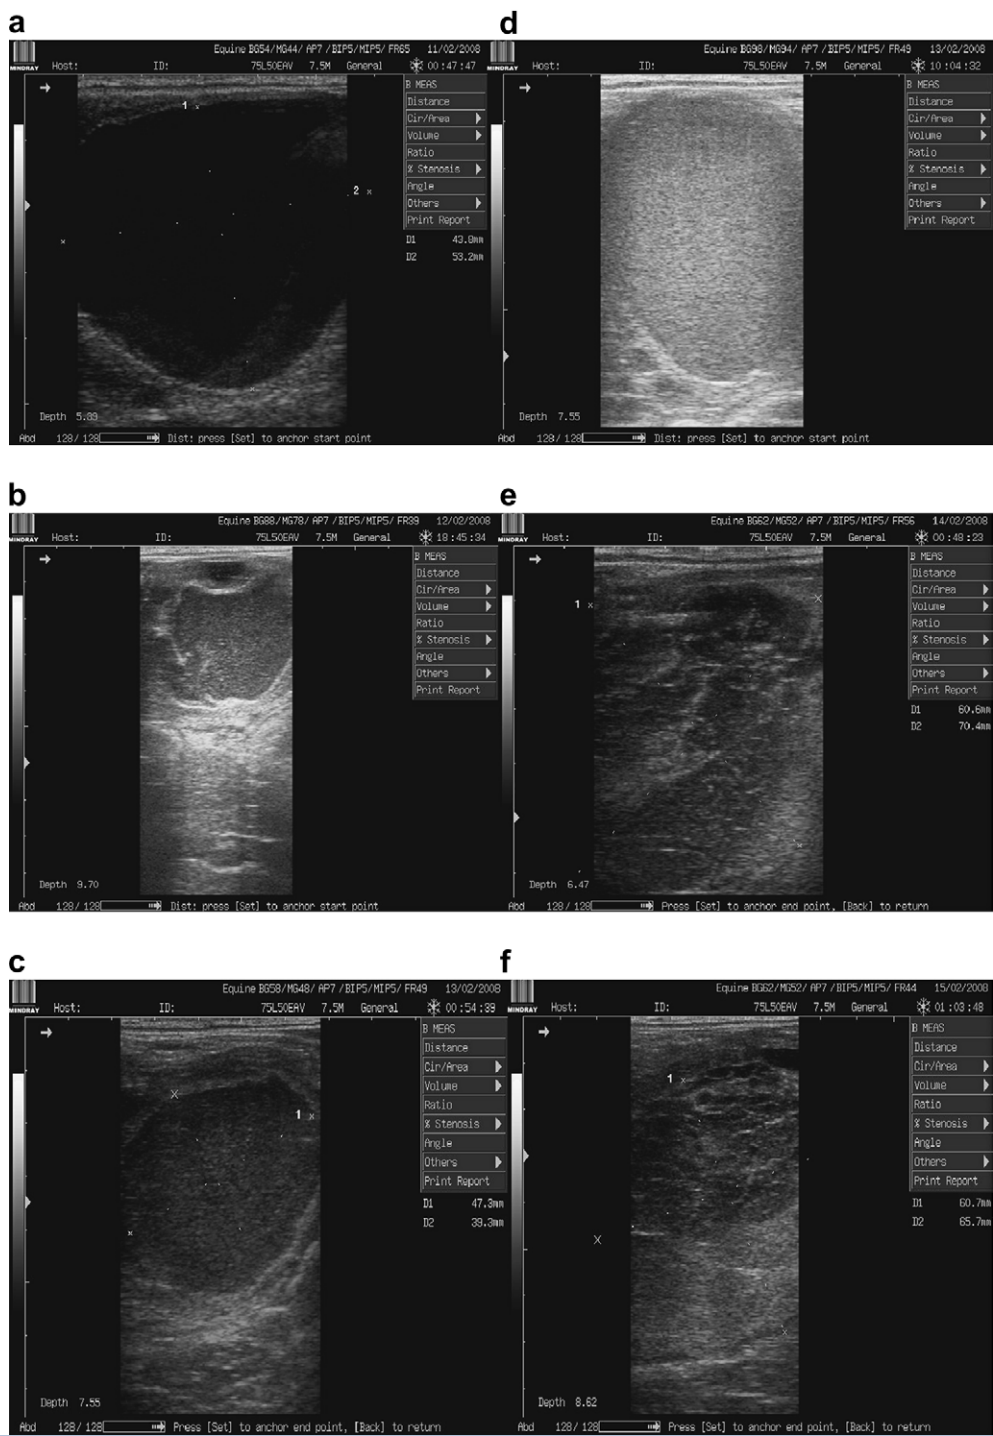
Chronological order of a sonogram series of a preovulatory follicle (a) that hemorrhaged and subsequently luteinised without loss of follicular fluid; (b) and (c) follicle fills with blood (hyperechoic specks), and follicular wall thickens and becomes hyperechoic; (d) increase in number of hyperechoic specks as a result of further hemorrhage; (e) and (f) organized follicular contents, luteal tissue becomes more apparent (lower part of pictures), and the overall diameter of the unruptured follicle increases to over 60 mm. Picture (b) is considered as hour 0 (beginning of hemorrhage); (a) – 42 hours; (c): + 6 hours; (d): + 16 hours; (e) + 30 hours; (f) + 54 hours.
